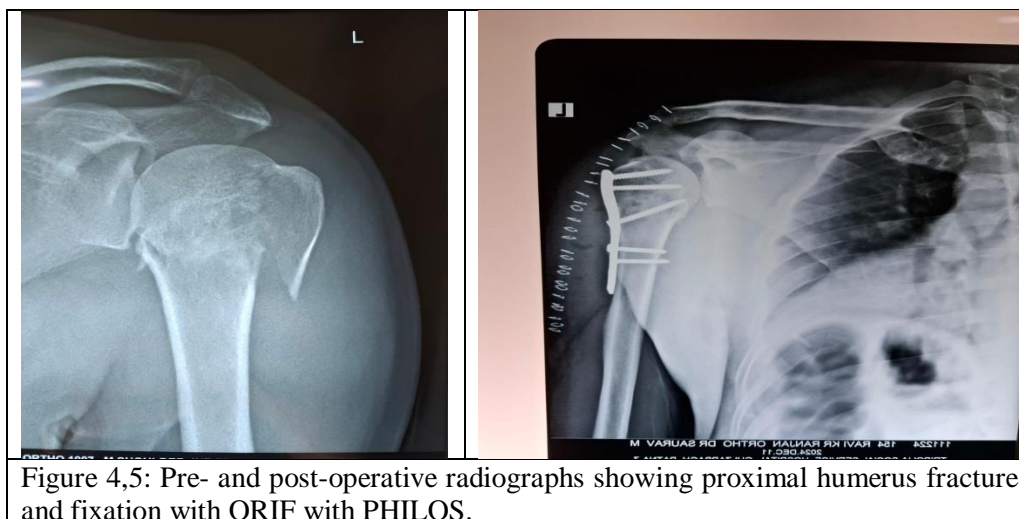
Pre- and post-operative radiographs showing proximal humerus fracture and fixation with ORIF with PHILOS.
